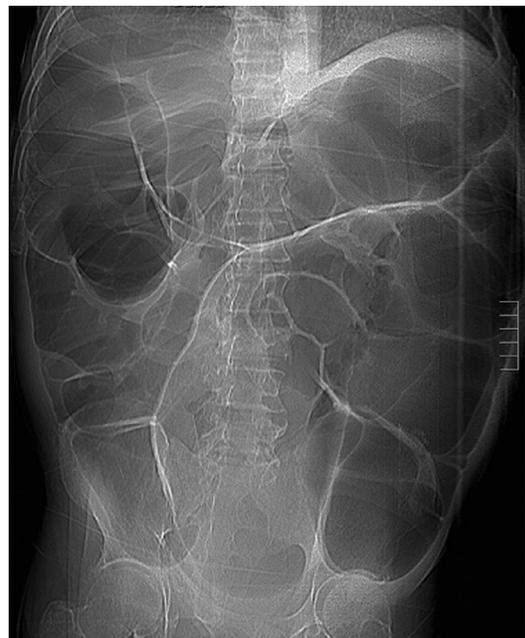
Plain film in a patient with ACPO secondary to Tuberculosis. Courtesy of Samuel Eisenstein, M.D., University of California, San Diego.
